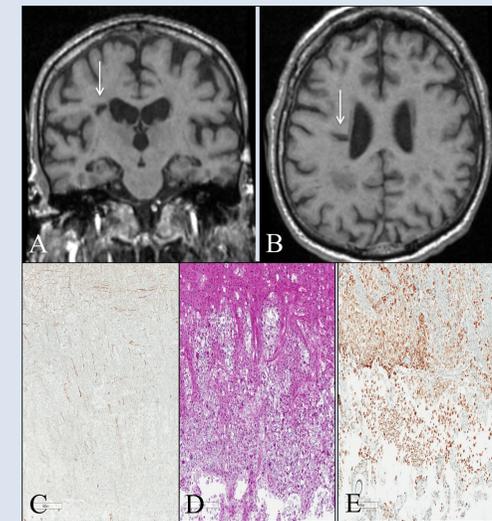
PVIs. A & B - coronal T1 MRI with PVI (white arrow). C- axonal loss on neurofilament; D - an influx of macrophages, confirmed on CD68 (E).
